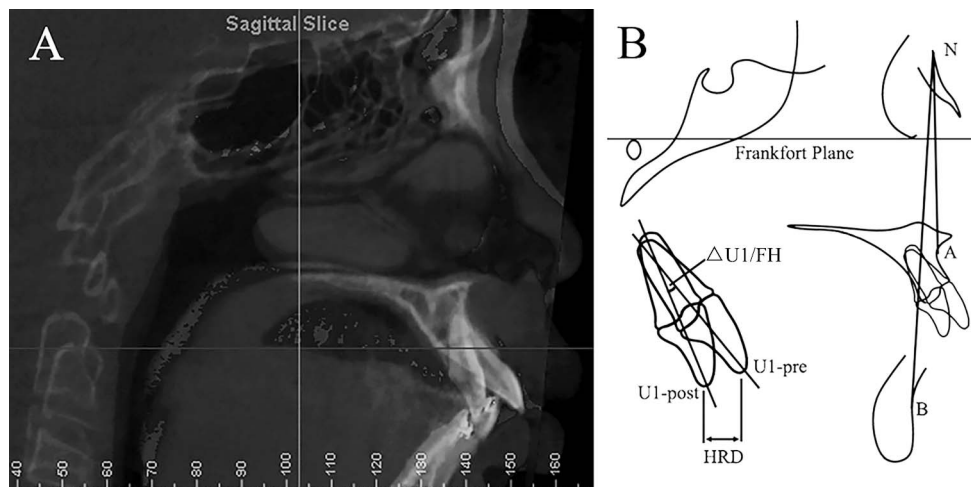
(A) Superimposition of pre- and postretraction CBCT; (B) Measurements: ANB, the angle between NA and NB; U1/FH, the angle between the long axis of U1 and the Frankfort plane; HRD (horizontal retraction distance), horizontal distance between the pre- and post-retraction incisal edge of U1.
